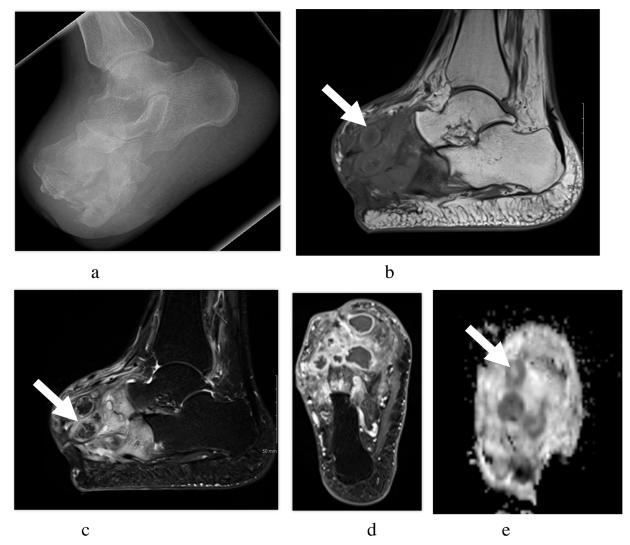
Madura foot. 29-year-old with foot pain and swelling. Prior partial amputation after foot was beaten with a hammer, complicated with chronic pain and discharge from foot. Lateral Xray (a) of foot shows partial amputation, mixed bone lysis and sclerosis with surrounding soft tissue swelling. Sagittal T1W (b) and STIR (c) images show target lesions (arrows) with surrounding bone osteomyelitis. Axial T1W post contrast images (d) shows rim enhancing lesions of abscesses. Axial ADC map (e) shows the restricted areas with target sign (arrow).
